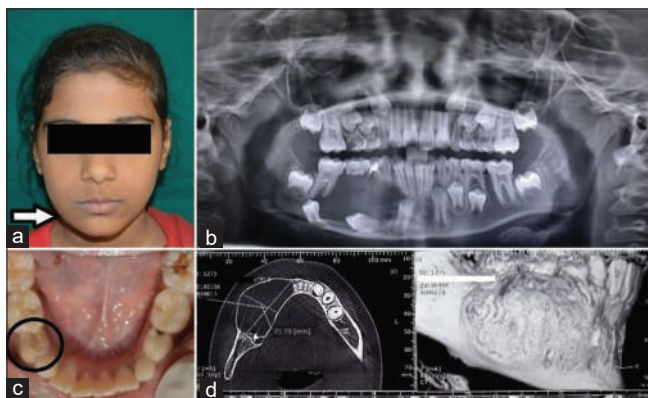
Preoperative pictures. (a) Extraoral swelling on right side of face (arrow) with facial asymmetry (b) Vestibular obliteration (circled) at 84, 85 (c) Orthopantomogram showing single homogenous radiolucency in the region of 83, 84, 85, 46 (d) Cone beam computed tomography showing expansion of buccal and lingual cortical plates
